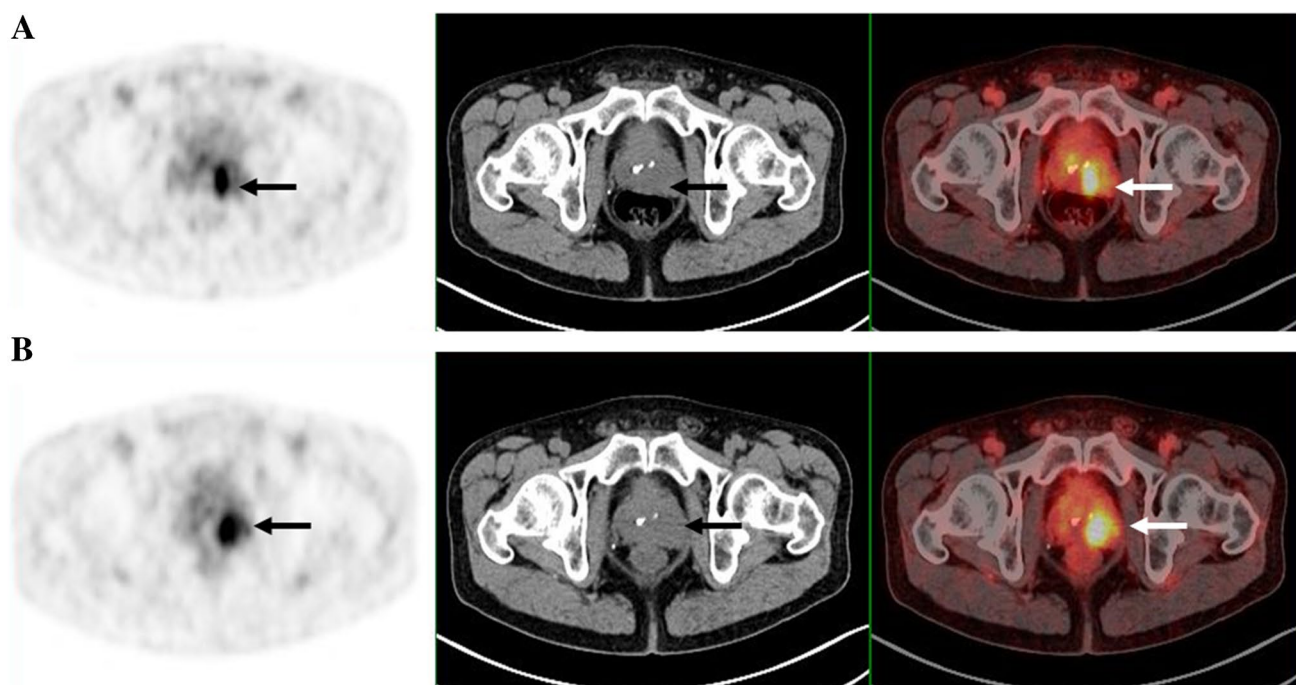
Images from [^{68}Ga]Ga-P137 PET/CT (A) and [^{68}Ga]Ga-PSMA-617 PET/CT (B) show intense tracer uptake at primary focus of prostate cancer site (arrow pointed) in patient 1. Left images: PET images. Middle images: axial CT images. Right images: axial-fused PET/CT images
